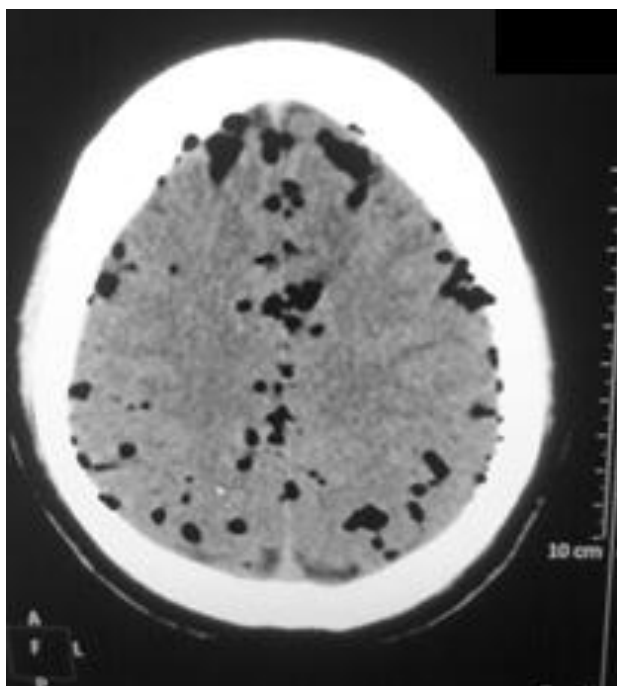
CT Axial Image showing Extensive Pneumocephalus with Underlying Fracture
